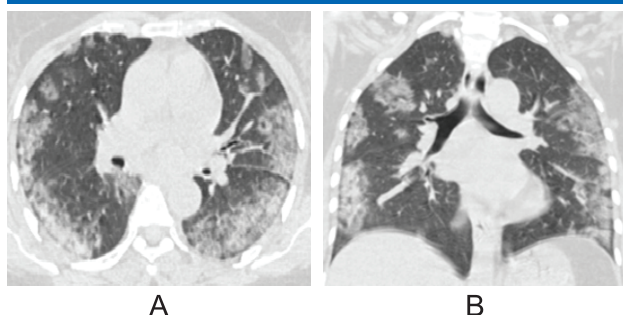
HRCT chest axial (A) and coronal (B) images show bilateral, multifocal, peripheral ground-glass opacities with septal thickening (giving a crazy-paving pattern). Findings consistent with COVID-19 pneumonia were reported and RT-PCR came out to be positive.
